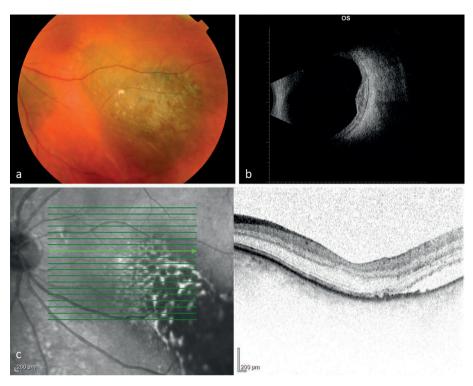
Pigmented uveal melanoma with orange pigment (lipofuscin). Figure 4b. A homogeneous grey scale in the tumour and choroidal excavation on B-scan ultrasonography. Figure 4c. Optical coherence tomography of the same tumour with subretinal fluid.
